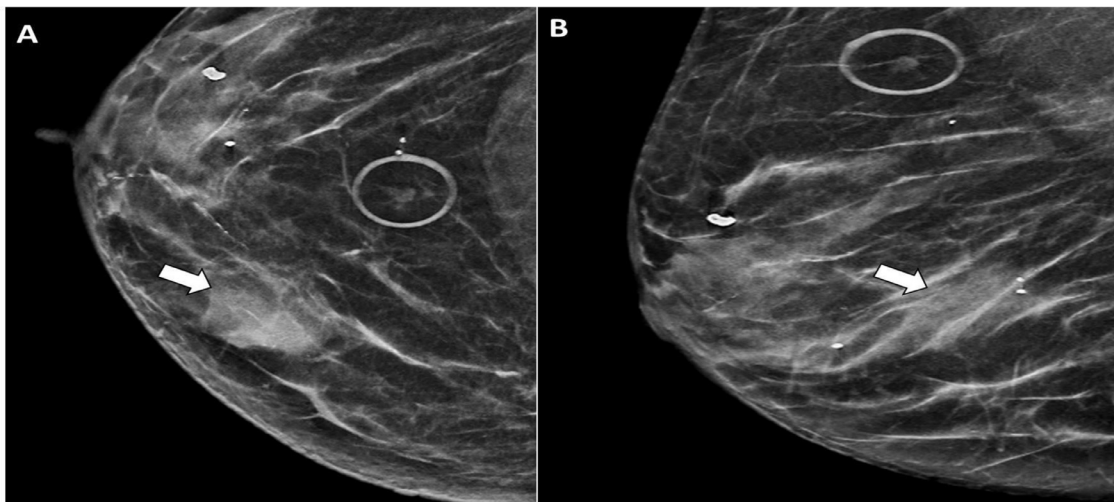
Craniocaudal (A) and mediolateral (B) mammography images of the right breast synthesized from digital breast tomosynthesis (DBT) revealed an oval, high density mass with obscured margins (arrows) which corresponded to CTA findings.
